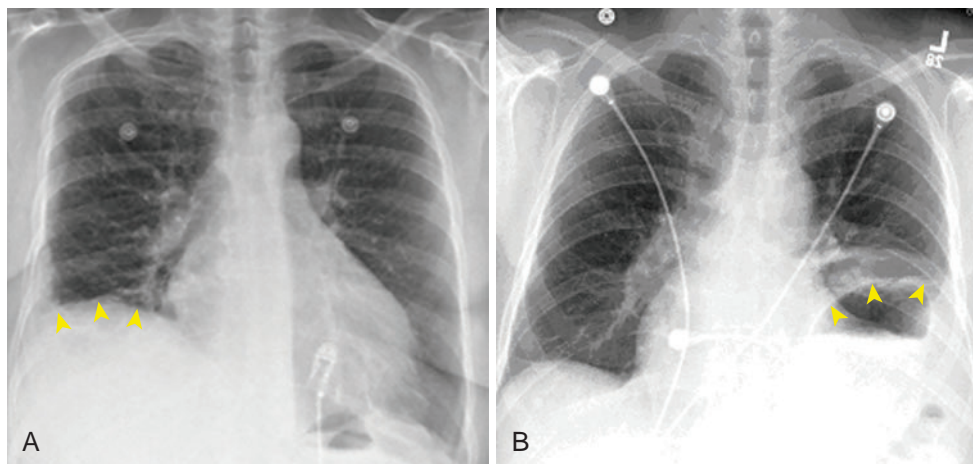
Hemidiaphragmatic Paralysis Secondary to Phrenic Nerve Injury. Chest x-rays (posteroanterior views) showing right hemidiaphragmatic paralysis (arrowheads) caused by right phrenic nerve injury (A), and left hemidiaphragmatic paralysis caused by left phrenic nerve injury (B) during catheter ablation of atrial fibrillation.
